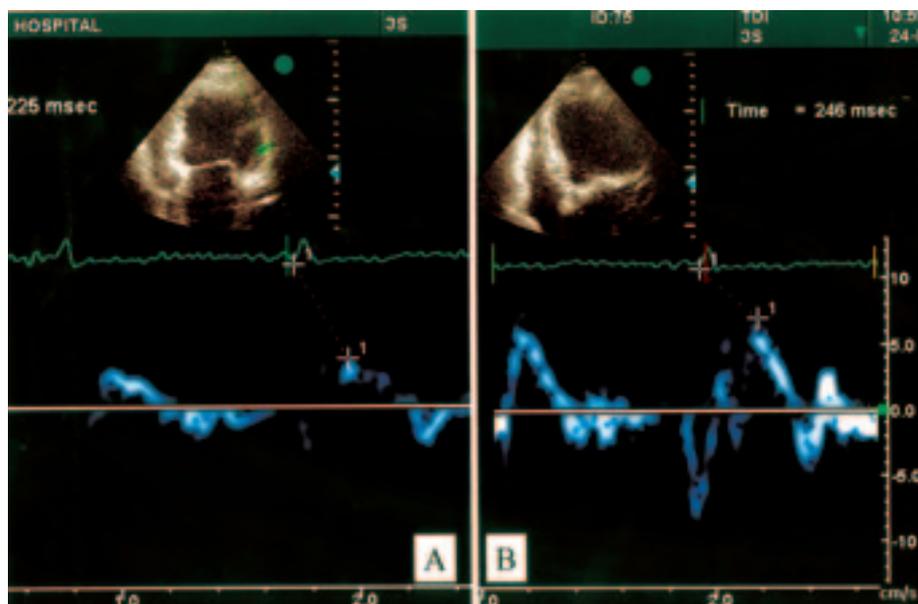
Assessment of interventricular dyssynchrony with the aid of tissue Doppler imaging. A: Measurement of the time interval from the start of the QRS to the occurrence of the peak systolic velocity of the left ventricular lateral wall in the apical four-chamber view (lateral wall T_s). B: Measurement of the time interval from the beginning of the QRS to the occurrence of the peak systolic velocity of the right ventricular wall in the apical four-chamber view (right T_s). The difference [lateral wall T_s - right T_s] is an index of interventricular dyssynchrony.
